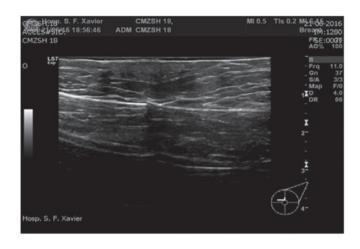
Ultrasonographic aspect of the tissue.
